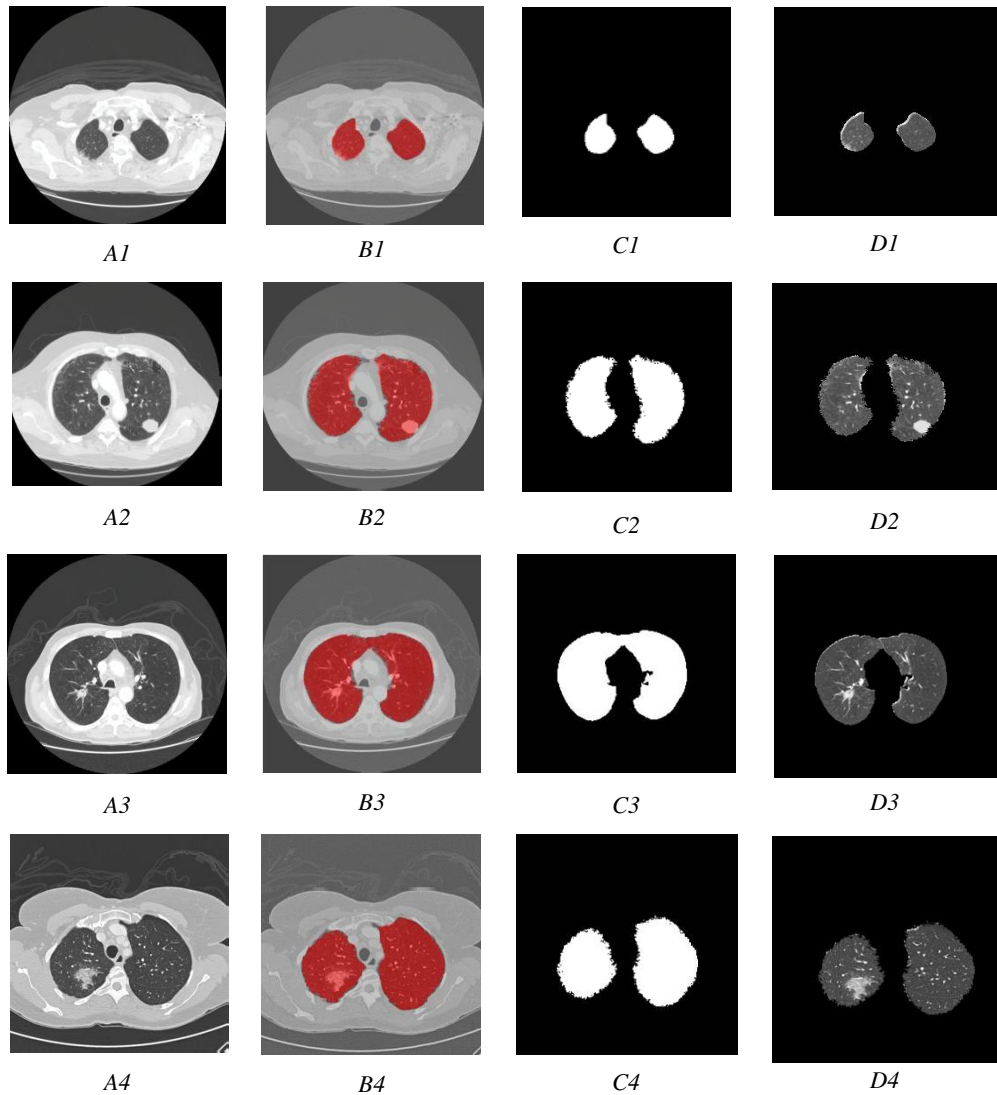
(A1,A2,A3,A4) raw CT lung images, (B1,B2,B3,B4) segmentation using the SegNet model, (C1,C2,C3,C4) binary mask, (D1,D2,D3,D4) segmented parenchyma
